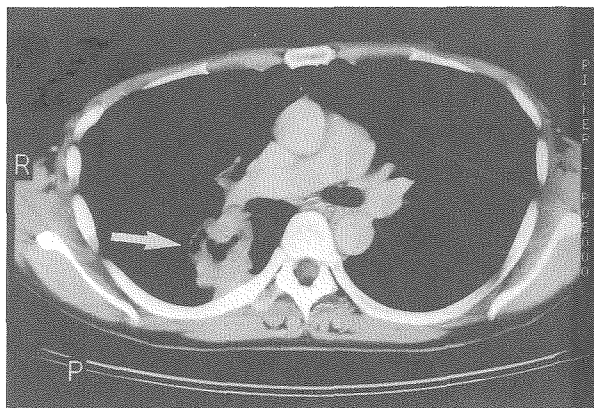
Chest CT scan shows multiple cavitory lesions (arrows) within the parenchyma of the lungs.
